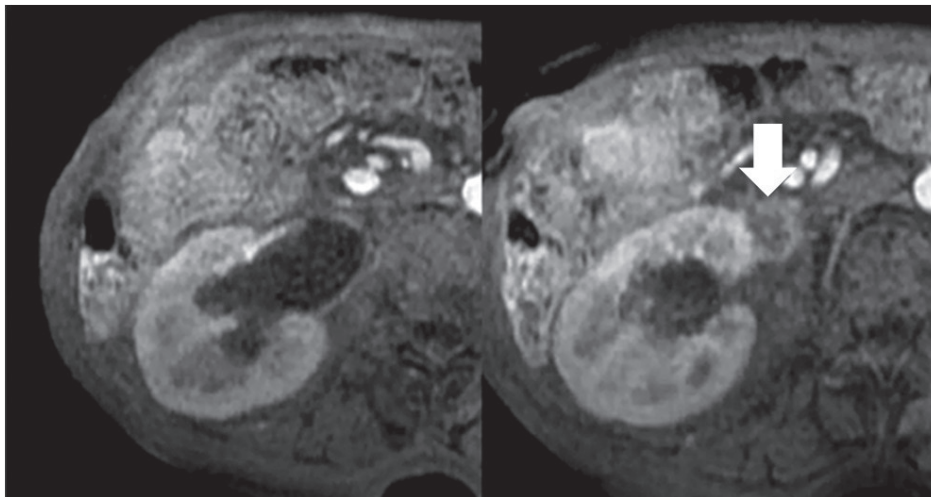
Axial fat suppressed contrast-enhanced T1W MR images show retroperitoneal tumour relapse, resulting in infiltration and dilatation of the right renal pelvis.
